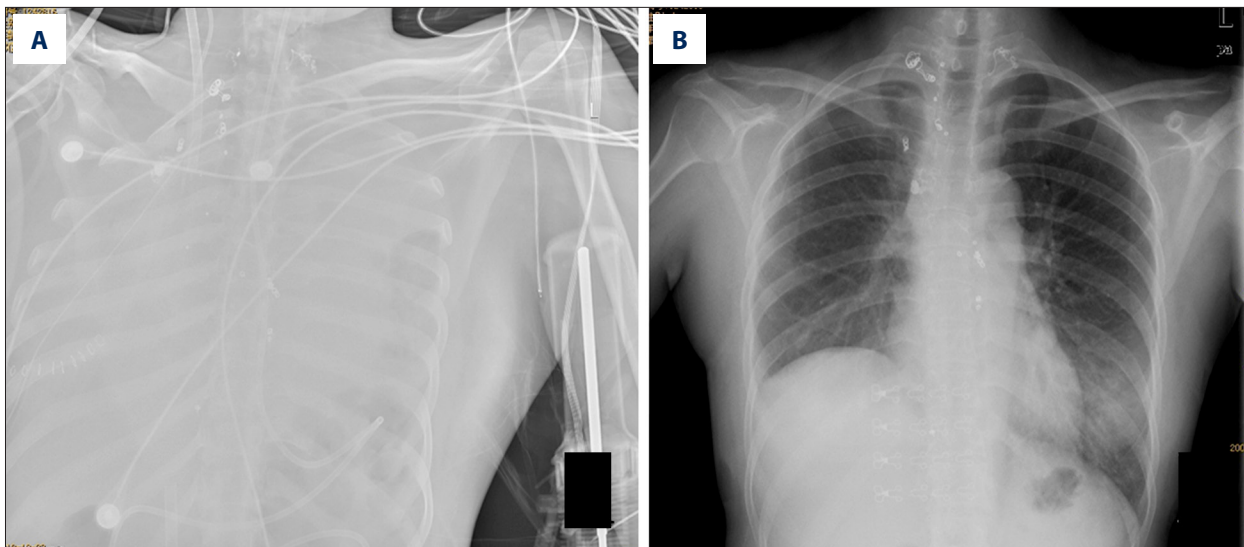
Pre- and postoperative X-ray images from case 13 admitted for repeated hemoptysis. (A) Preoperative X-ray revealed complete whiteout of the lungs due to bleeding from a branch of the right bronchus. (B) Postoperative X-ray prior to discharge shows resolution of whiteout.
